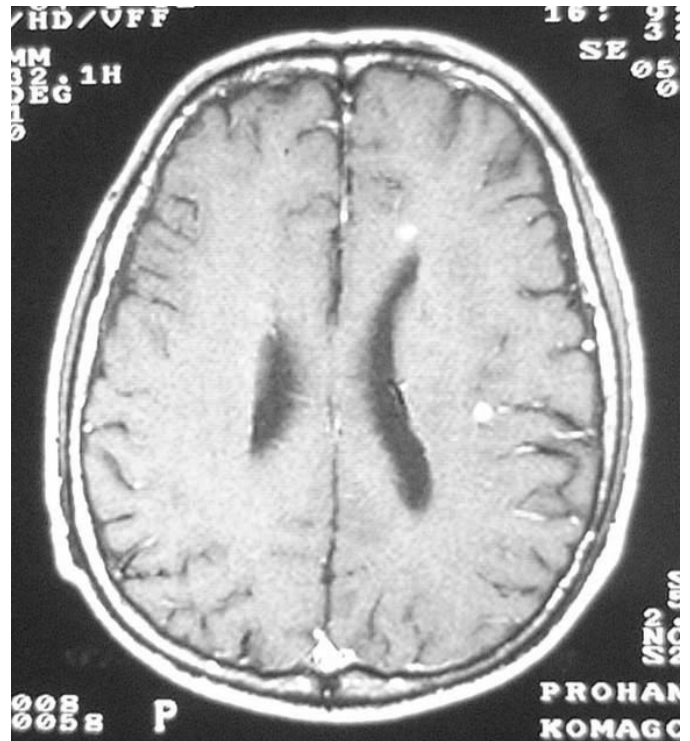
Magnetic resonance imaging of the brain detected multiple brain metastases (February 2003).
